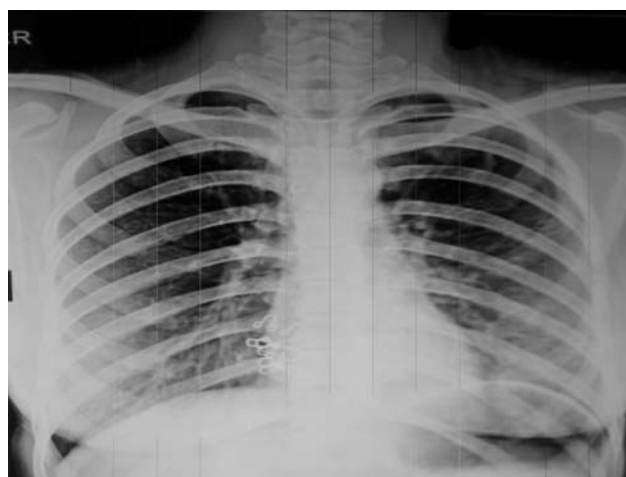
Chest radiograph (postero-anterior view) showing left lower zone haziness.
